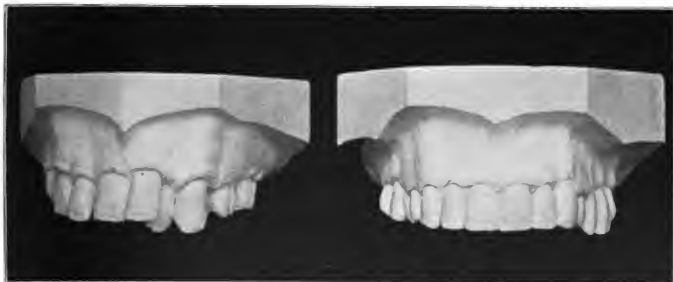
Mal-occlusion. Spreading of the two central incisors. Case treated fifteen years ago. Radiograph showing condition today with perfectly normal pulps. The holes for the platinum staple wire were drilled between the enamel wall and pulp chamber.
